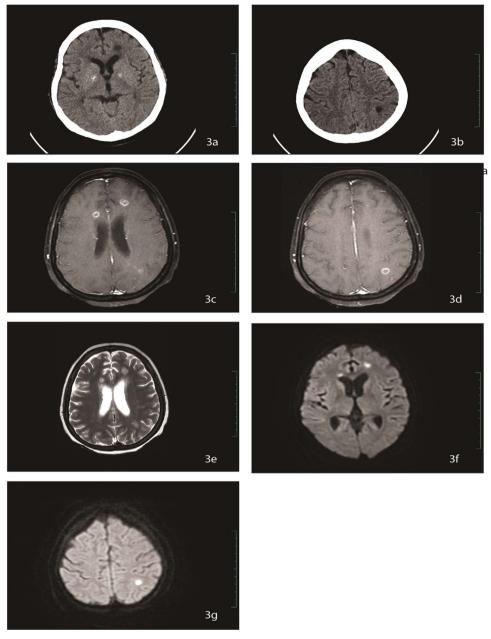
MRI image of brain showing hypodense lesions in the left parietal and bilateral frontal lobes.
